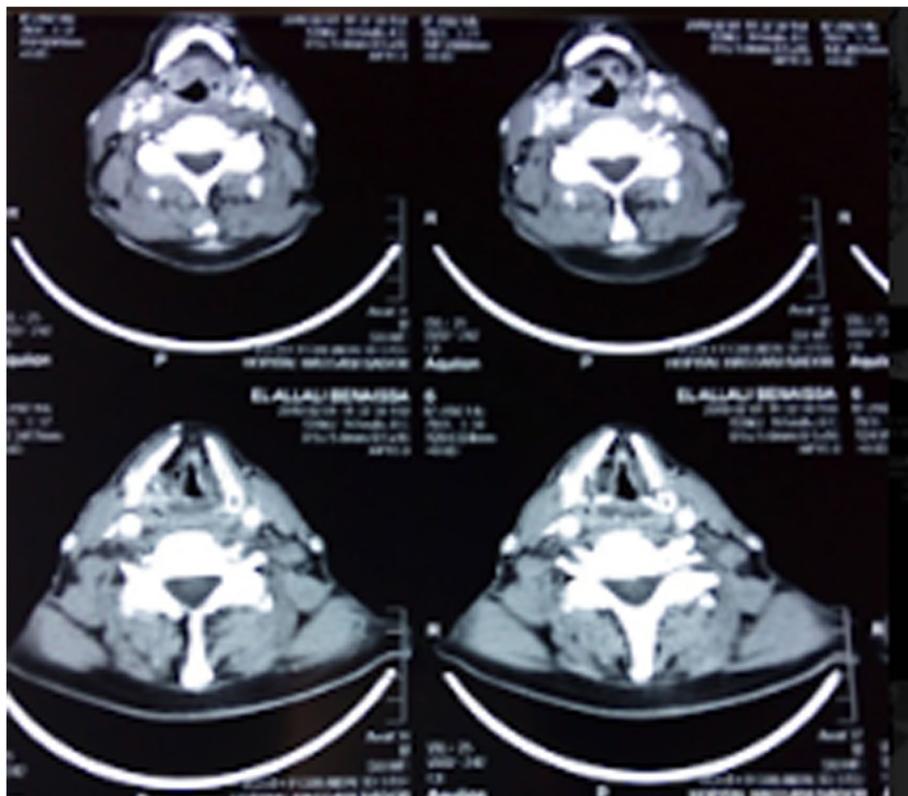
Axial CT scan sections: thickening of laryngeal mucosa at the level of the thyroid cartilage and cricoid cartilage, with complete obstruction
